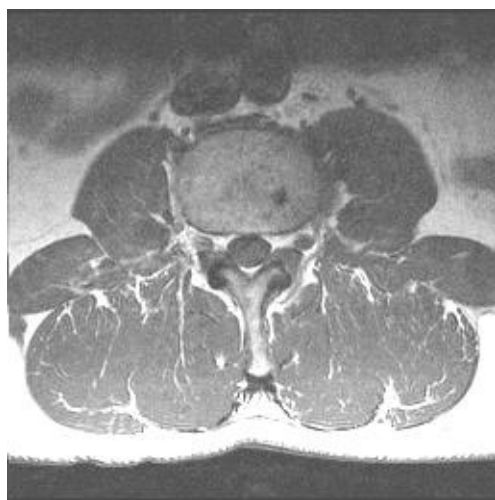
Transverse spin echo T1-weighted lumbar spine image. *TR*, 736 ms; *TE*, 15 ms.
